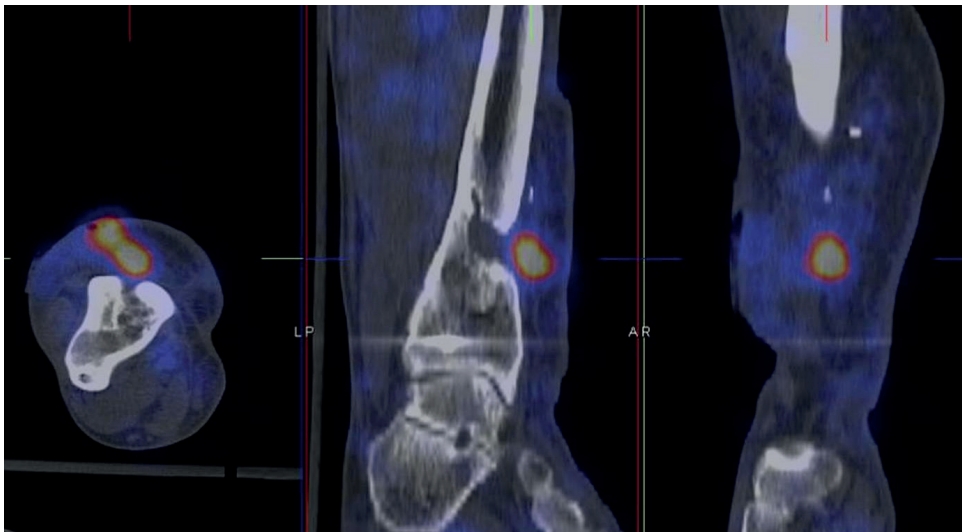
WBC scan SPECT-CT of patient A.
